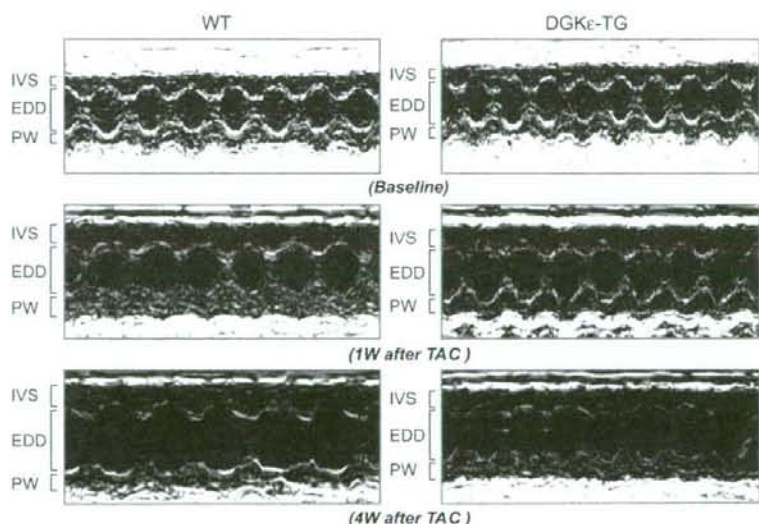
Representative M-mode echocardiograms at baseline, 1 wk (1w) and 4 wk (4w) after TAC surgery. IVS, interventricular septum; EDD, left ventricular end-diastolic dimension; PW, posterior wall.
